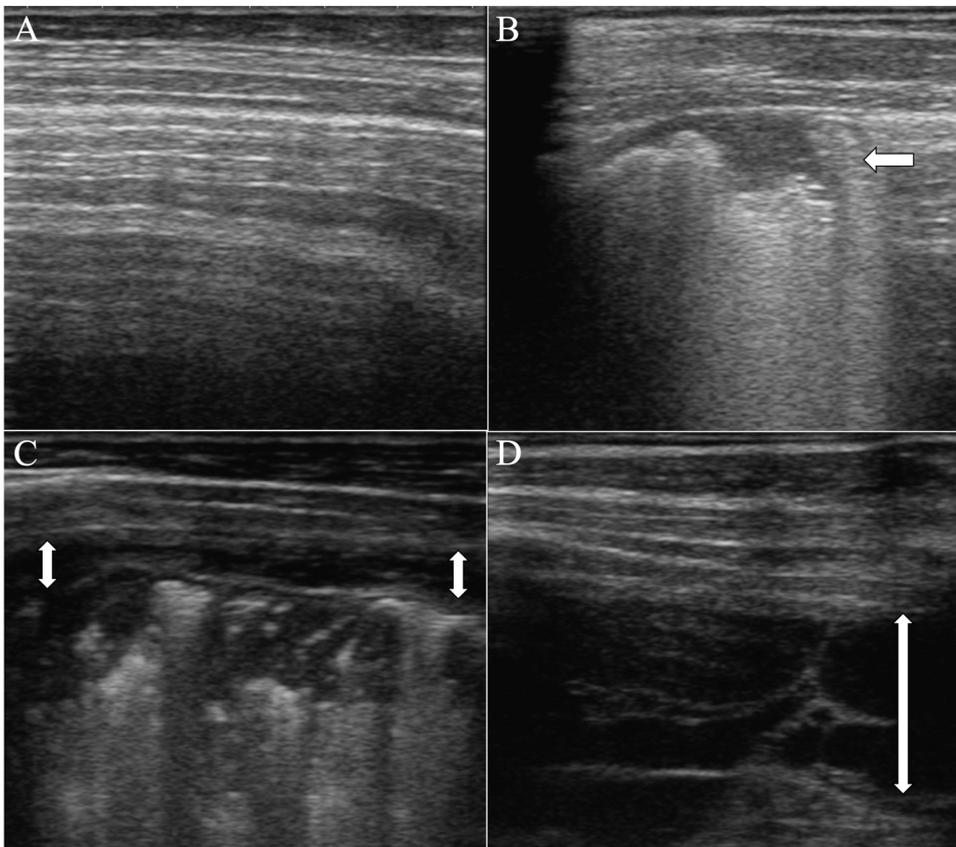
Ultrasonographic findings in the lungs of calves. A. Normal lung. The parallel horizontal white lines are A-lines (reverberation artifact) and are characteristic of healthy lungs. B. Lung (Calf B8), 24 h after *M. haemolytica* infection. The lung contains an area of consolidation (arrow) that is hypoechoic and lacking reverberation artifact. C. Lung (Calf B6), 48 h after *M. haemolytica* infection. The entire lung in this field is consolidated (hypoechoic and lacking reverberation artefact) and there is a small amount of pleural effusion identified as a black area (double arrows) between the body wall and the pleural surface of the lungs. D. Lung (Calf B6), 48 h after *M. haemolytica* infection. Some areas had a large amount of pleural fluid (double arrow) and fibrin strands between the pleural surfaces.
